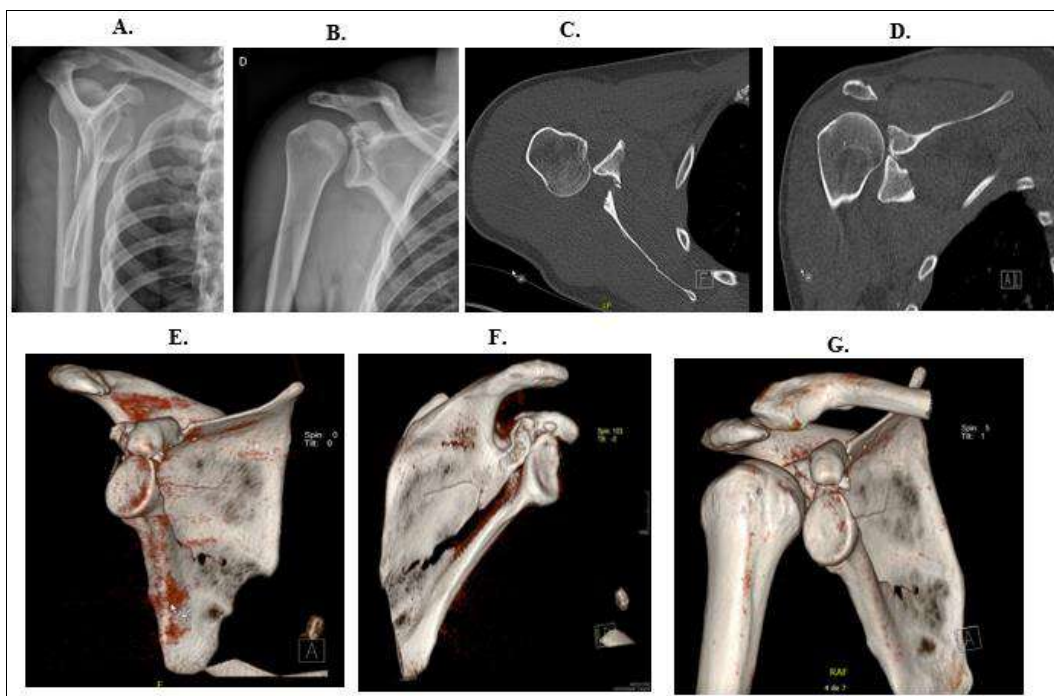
Radiographs and CT scan with 3D reconstructions are showing anterior displacement of the glenoid surface and vault together with the lateral pillar of the scapula.
